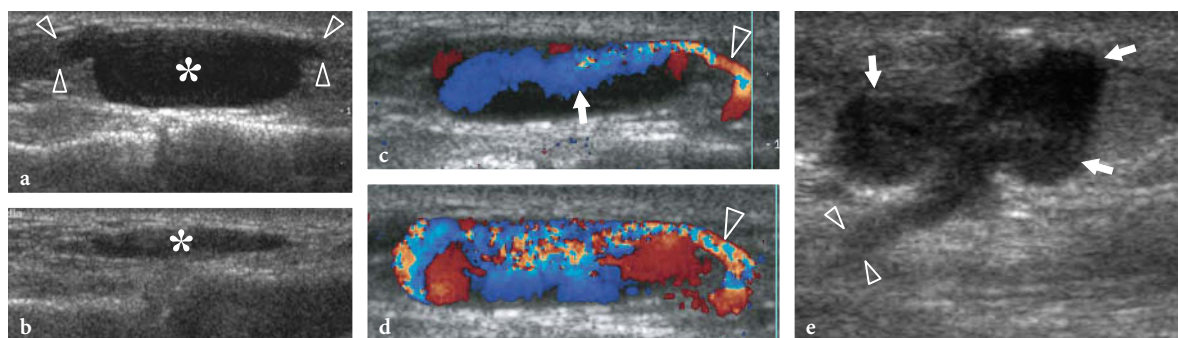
Venous aneurysms. Two different cases. Long-axis a,b gray-scale and c,d color Doppler 12–5 MHz US images obtained a,c,d without and b with probe compression over a compressible soft-tissue mass of the dorsum of the mid-foot in a patient with healed mid-tarsal fractures reveal a fluid-filled oval lesion (*asterisks*) connected at its opposite ends to a small superficial vein (*arrowheads*). As shown in b, the mass is fully compressible without internal thrombus. This sign, together with demonstration of the venous ends and of internal blood flow at color Doppler imaging, may avoid confusion with ganglion cysts. While releasing probe compression, blood flow (*arrow*) can be seen entering the aneurysm from the parent vein (*arrowhead*) to completely fill its cavity. e Thrombosed superficial varicose vein. Sagittal 12–5 MHz US image over the posteromedial aspect of the leg shows a polycyclic hypoechoic mass (*arrows*) in continuity with a thin pedicle (*arrowheads*) directed toward depth, an appearance nonspecific at US examination. After surgical resection, this mass proved to be a thrombosed varix
